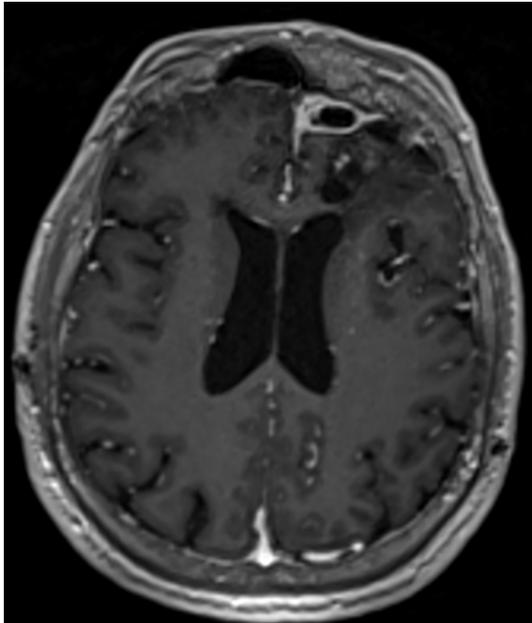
An axial T1 contrast MRI displaying enhancement of the tumor cavity but no evidence of residual tumor.
